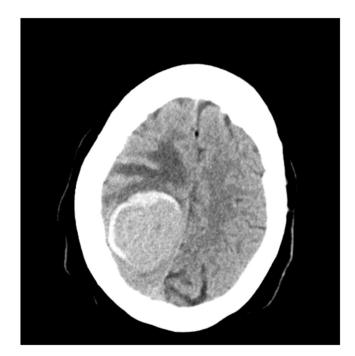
Computed tomography (CT) scan of the brain in axial view revealing a dural-based right parietal hyperdense mass with surrounding edema, mass effect, compression of the right lateral ventricle's atrium and a right-to-left midline shift.
